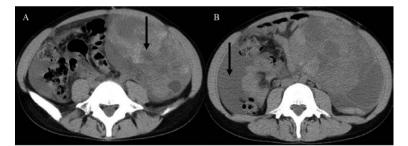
Computed Tomography CT at 6 months after chemotherapy cessation revealed a large ovarian mass (A) and ascites (B).
